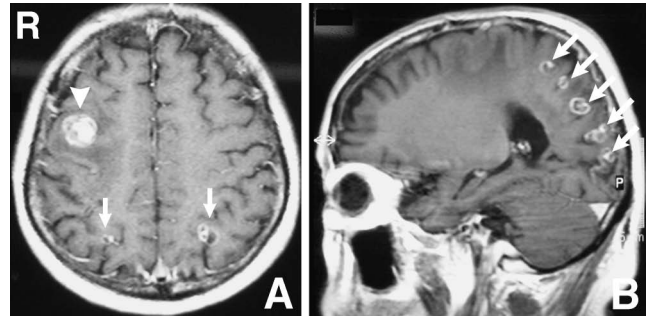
Preoperative axial (A) and sagittal (B) T₁-weighted magnetic resonance images after gadolinium infusion demonstrating subcortically located, heterogeneously enhanced, multiple tumors in the bilateral frontoparietal and occipital lobes (arrows), with a lesion located in the right frontal lobe (arrowhead).
